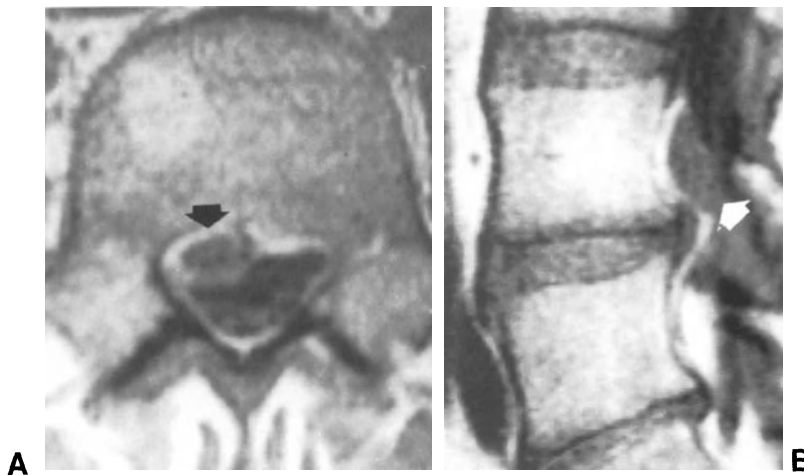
MR images of a migrated herniation. (A) Axial scan showing a disc fragment migrated cranially to the L4-L5 disc (arrow). (B) Sagittal scan showing the proximity of the large migrated disc fragment (arrow) to the fourth lumbar disc, from which it originated. This disc appears to be protruded and was evacuated.
